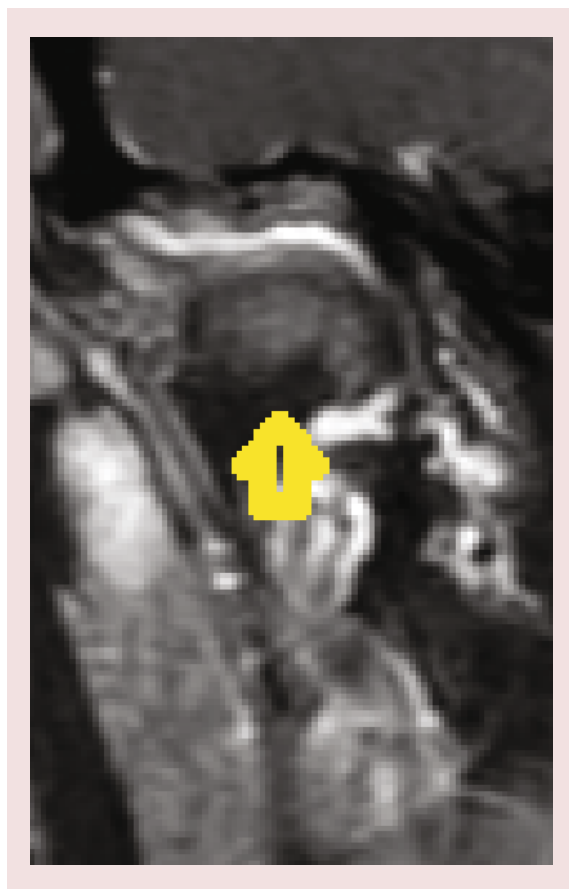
Temporomandibular joint MRI (coronal T1-weighted post-contrast image) of same subject. Condylar bone loss (arrow) is more evident on this Figure.
